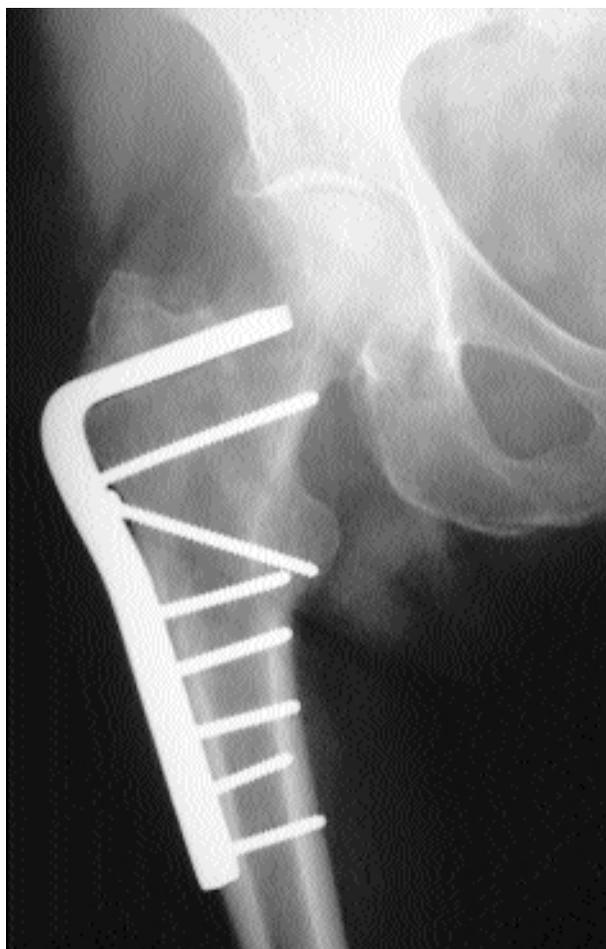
Radiograph (anteroposterior view) of a subtrochanteric fracture treated by way of internal fixation with a blade plate.
